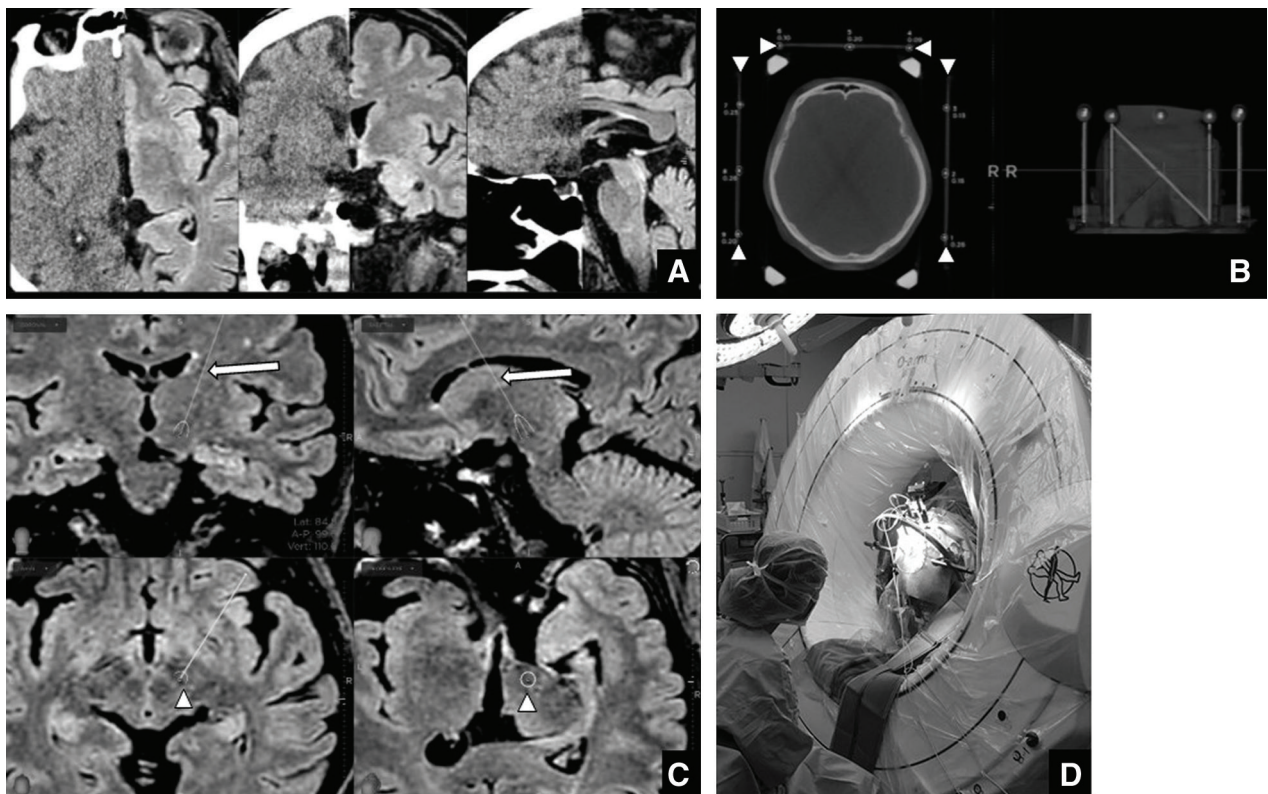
Steps for image fusion and surgical planning. (A) Process of fusion image production from preoperative MRI and CT images by O-arm using FrameLink. (B) 3D image by O-arm after fitting the stereotactic frame and CT indicator. This shows the recognition of the CT indicator (arrowheads) on FrameLink. (C) To start, a platform with common coordinates for the different modalities is produced by fusing the preoperative MRI and CT images with the 3D CT images by O-arm. Next, the target (arrowheads) is designated on FrameLink using MR images on the common platform, via a route (arrows) that avoids the cerebral sulcus, cerebral ventricles, and vascular structures. (D) Intraoperative MER being conducted near the O-arm 2 gantry does not interfere with the O-arm being used for DBS. CT: computed tomography, DBS: deep brain stimulation, MER: microelectrode recording, MRI: magnetic resonance imaging, 3D: three-dimensional.
